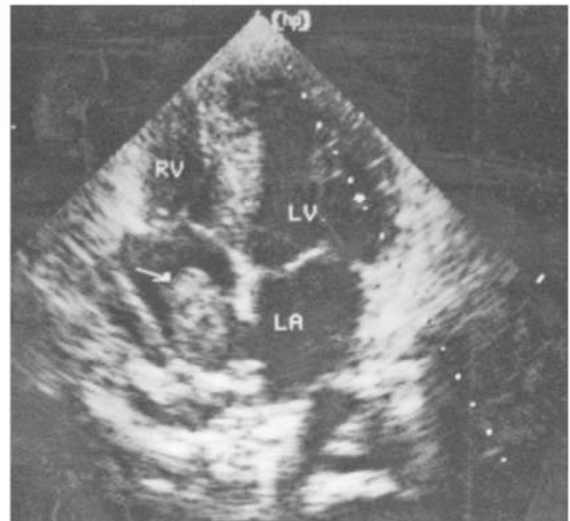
• Echocardiography revealing TT (white arrow) extending into the RA.
